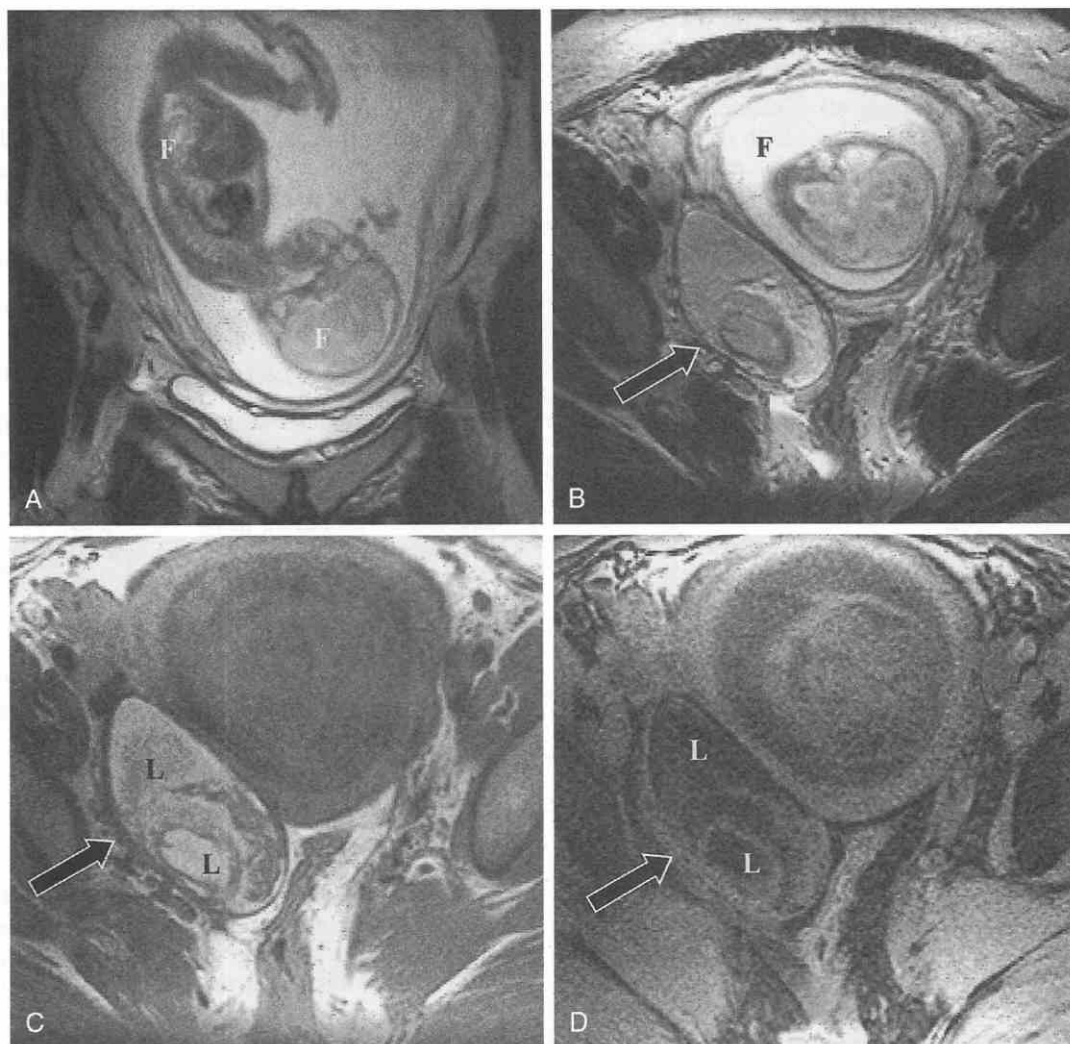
Mature cystic teratoma, chemical shift imaging. A, Coronal image shows normal fetal anatomy (F) at 22 weeks of gestation. B, T2-weighted image shows the gravid uterus (F) and a complex right adnexal mass (arrow). The mass does not have the signal features of simple fluid. T1-weighted gradient-echo images with (C) and without (D) fat suppression show loss of signal of the lipid component (L) in the mass (arrow), establishing the diagnosis of a mature cystic teratoma. (From Ascher SM, Outwater EK, Reinhold C: Adnexa. In Semelka RC, Ascher SM, Reinhold C [eds]: *MRI of the Abdomen and Pelvis: A Text-Atlas*. New York, Wiley-Liss, 1997, pp 661-715.¹²)
